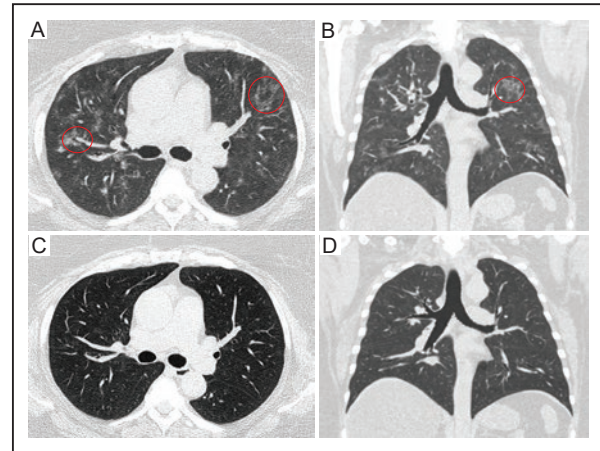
Chest CT of a 75-year-old female diagnosed with COVID-19. A: coronal and B: axial baseline images showing multifocal areas with ground-glass opacity with bilateral diffuse distribution (circles). C: coronal, and D: axial images of follow-up, taken 6 months after the initial infection showing complete resolution of the baseline pulmonary tomographic findings.
